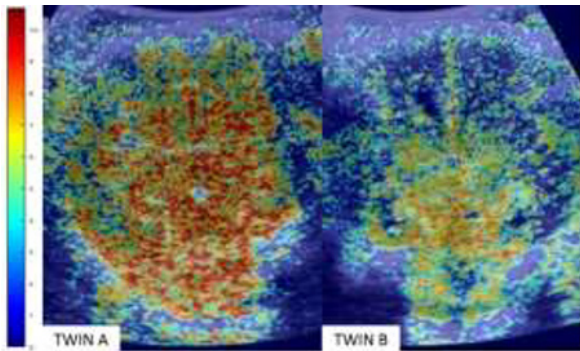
Coronal Parametric maps of the brain created from contrast-enhanced ultrasound performed in premature fetal lambs maintained on the EXTEND system demonstrating decreased parenchymal enhancement in Twin B concordant with known hypoxic injury when compared to Twin A.
